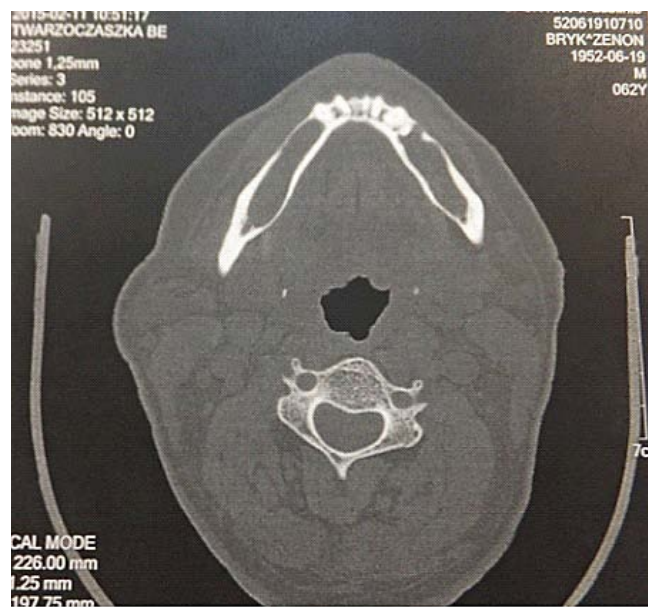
Axial projection CT, visible dentinogenous cysts, left-sided keratocyst and right-sided radicular cyst of the body of the mandible
